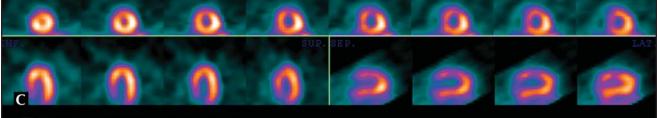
A, A 31-year-old woman with chest pain at admission. B, A 45-year-old woman with chest pain at admission. Both patients in *Panels A* and *B* experienced major emotional stress. Note the different pattern of left ventricular (LV) wall motion abnormalities in these end-systolic LV ventriculographies. C, Rest sestamibi single photon emission CT from the second case, showing normal perfusion 24 hours after admission.
